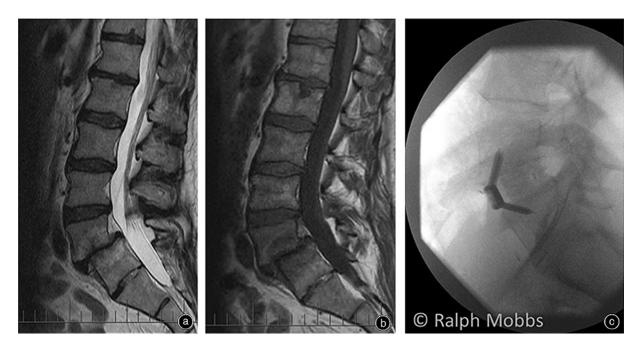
(A) T_2 MRI of a L_5S_1 spondylolisthesis. (B) T_1 MRI of a L_5S_1 spondylolisthesis. (C) X-ray after ALIF surgery with internal fixation and interbody device.
